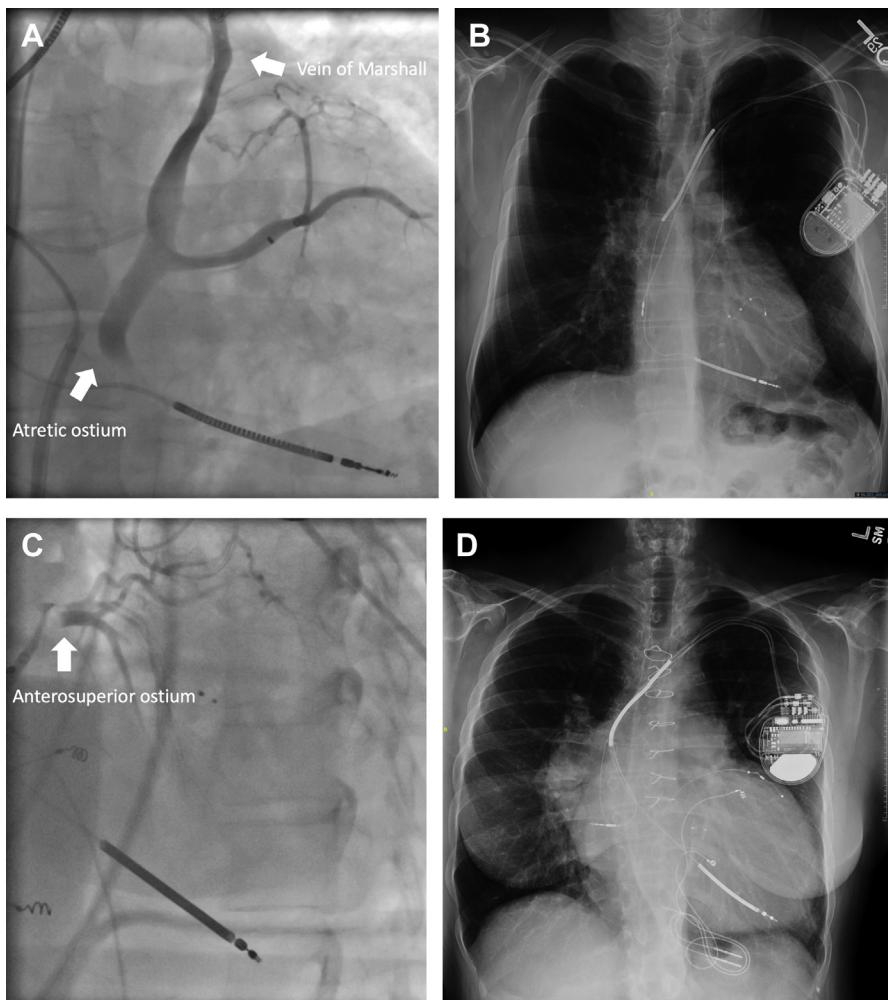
Transvenous cardiac resynchronization therapy lead placement for patients with CCTGA with absent or diminutive posteroseptal coronary sinus ostia (CSO). (A, B) Intraprocedural lead placement and postoperative radiograph for a patient with atresia of the posterior CSO. A lead was placed through a persistent vein of Marshall that drained the coronary venous circulation. (C, D) Identical views of a patient with a diminutive conventional posterior CSO with lead placement through a large vein at the base of the right atrial appendage.
